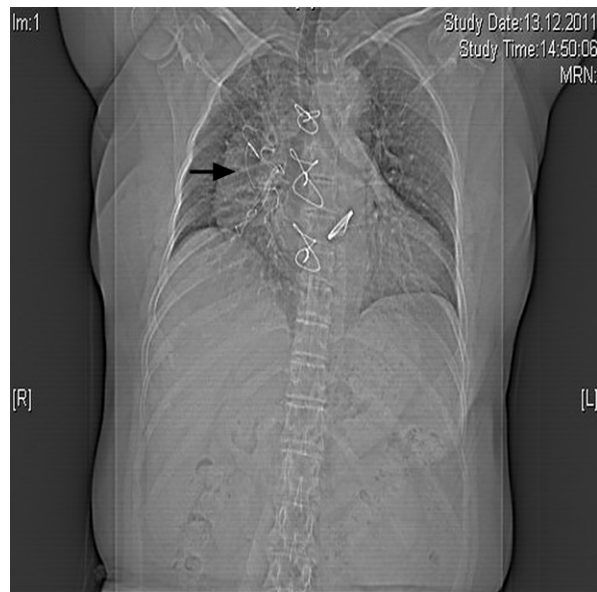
Patient 2. Computed tomogram (scout view) shows a radiopaque whorl lateral to the aorta.
